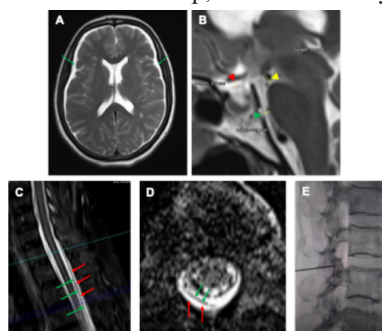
A) Axial T2-weighted MRI shows subdural effusion (green arrow). B) Sagittal T2-weighted MRI reveals effacement of the suprasellar (red arrowhead, pathologic ≤ 4 mm), prepontine cisterns (green arrowhead, pathologic ≤ 5 mm) and reduced mamillopontine distance (yellow arrowhead, pathologic ≤ 6.5 mm). C and D) Sagittal and Axial T2-weighted fat-suppressed images demonstrate dorsal epidural CSF collection (red arrow). The posterior dura is clearly delineated on both sagittal and axial views (green arrow). E) Fluoroscopic guided placement of needle at epidural space. at L3-L4 level.
